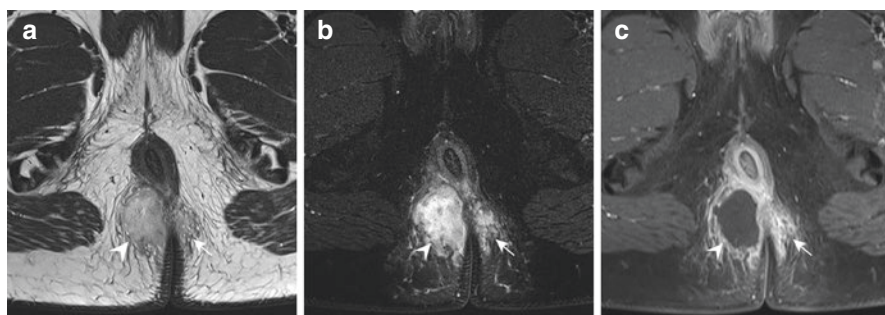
Perianal abscess (arrowhead), heterogeneous relatively hyperintense on a T2-weighted oblique axial sequence (a), heterogeneous hyperintense on an oblique axial T2-weighted fat-suppressed sequence (b), and a typical hyperintense rim enhancement with hypointense content (fluid/pus) on an oblique axial T1-weighted contrast-enhanced sequence (c). The short arrow indicates inflammation in the surrounding fat tissue. MRI is often not indicated for superficial perianal abscesses; clinical examination is mostly sufficient to establish the need for drainage or if needed ultrasound or computed tomography can be performed in the acute setting. However, MRI can help in assessment of extension and course of additional fistula tracts and in some cases to establish the presence of an abscess
